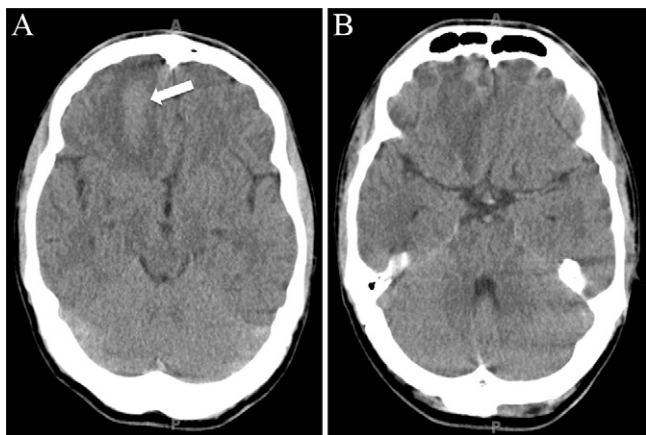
Non-contrast CT scans of the brain showing a hyperdense intraaxial lesion in the right frontal medial orbital gyrus (A, arrow), and adjacent cerebral edema (B).
